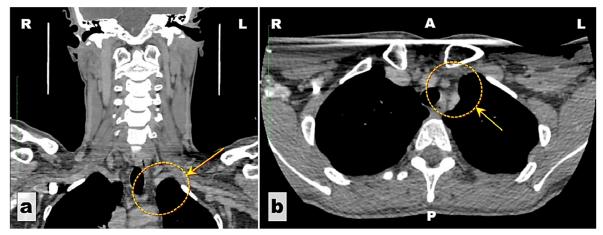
CT five years after surgery: (a) Coronal view – normal aspect (yellow circle and arrow); (b) Axial view – normal aspect (yellow circle and arrow). A: Anterior; CT: Computed tomography; L: Left side; P: Posterior; R: Right side.
